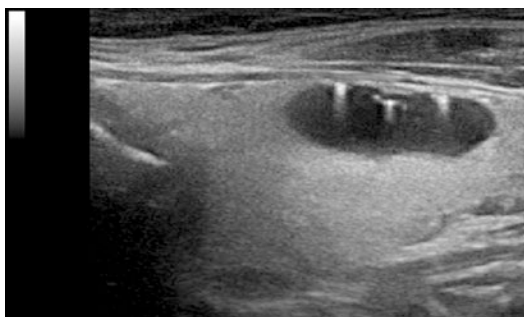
“Comet tails.” Colloid nodules and cysts may contain tiny crystals resulting from the desiccation of the gelatinous colloid material. Reflection of the sound waves off of the crystal results in a bright spot. However, in contrast to a soft tissue calcification, the crystals begin to vibrate under the influence of the ultrasound energy. The vibration generates sound waves, which return to the transducer after the initial reflected signal, resulting in the “tail”
